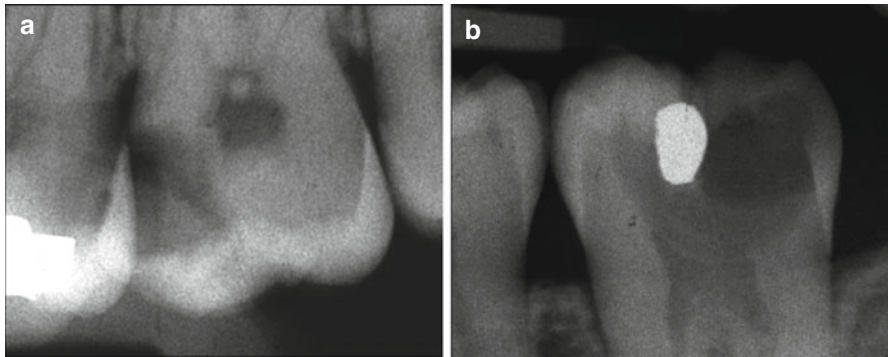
The radiographic presentations are shown of a deep caries lesion versus an extremely deep lesion. (a) The deep lesion involves the pulpal quarter with a radiodense zone separating the translucent zone from the pulp. (b) The extremely deep lesion defines a penetration that involves the entire primary/secondary dentin, either with no radiodense zone separating the demineralized dentin from the pulp or with a radiodense zone located within the pulp chamber indicative of tertiary dentin
